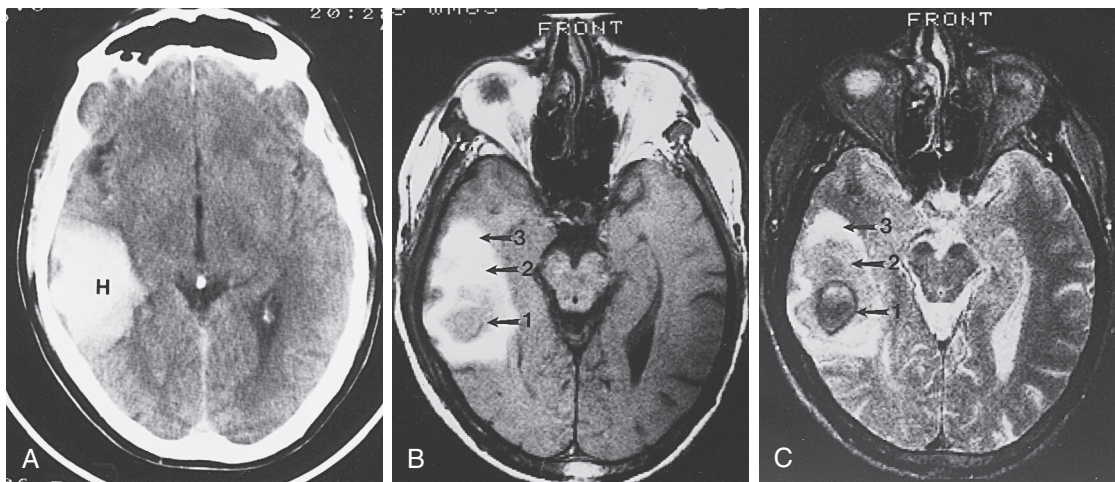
■ Hemorrhage. Axial computed tomography image (A) demonstrates a large area of acute hemorrhage (H) in right temporal lobe. T1-weighted (B) and T2-weighted (C) magnetic resonance imaging scans demonstrate the hemorrhage in various stages of breakdown. Center of lesion is dark on T1- and T2-weighted images, indicating oxyhemoglobin (1). Intermediate zone is bright on T1-weighted image and gray on T2-weighted image, indicating intracellular methemoglobin (2). Outer rim is bright on both T1- and T2-weighted images, indicating extracellular methemoglobin (3).
